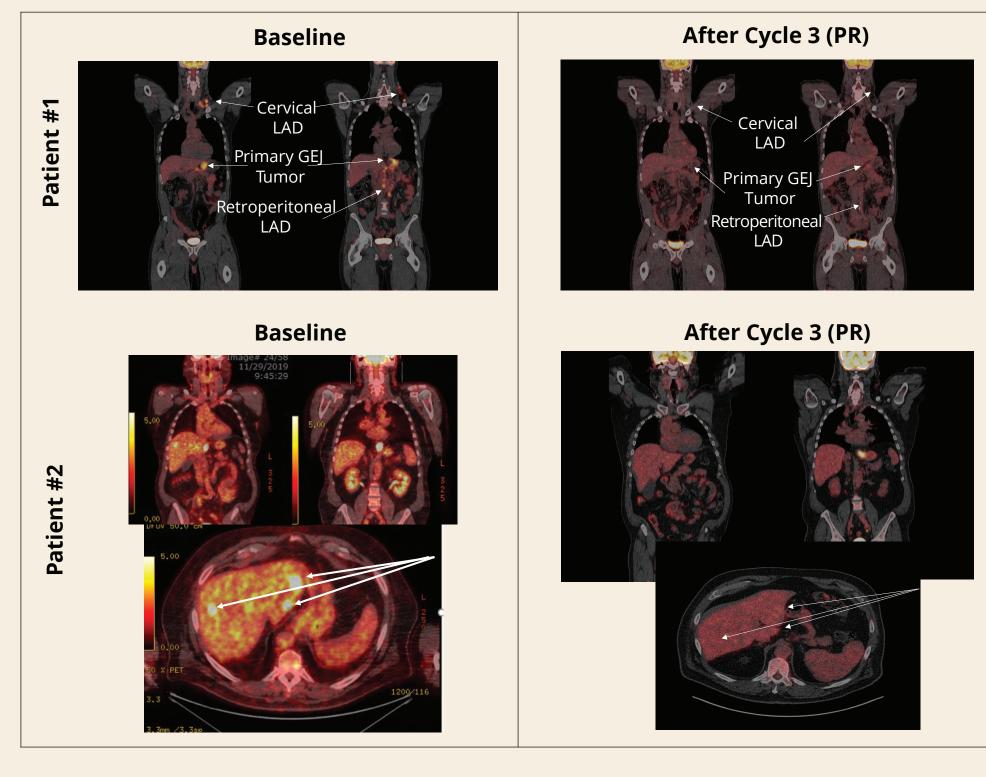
Radiographic Scans of Two Patients Who Achieved PRs After Treatment With Margetuximab + Retifanlimab
